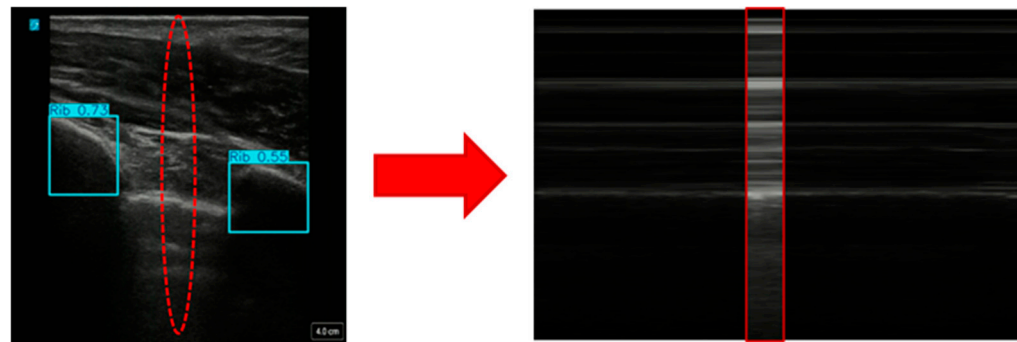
Overview of how M-mode images were generated from B-mode frames using rib guidance AI models. Shown first is a traditional B-mode ultrasound frame from which the guidance AI determined the location of the ribs (blue bounding boxes). A 3-pixel-wide region at the midpoint between the bound boxes (red dotted region) is selected across each frame to create a custom M-mode image (shown on the right).
